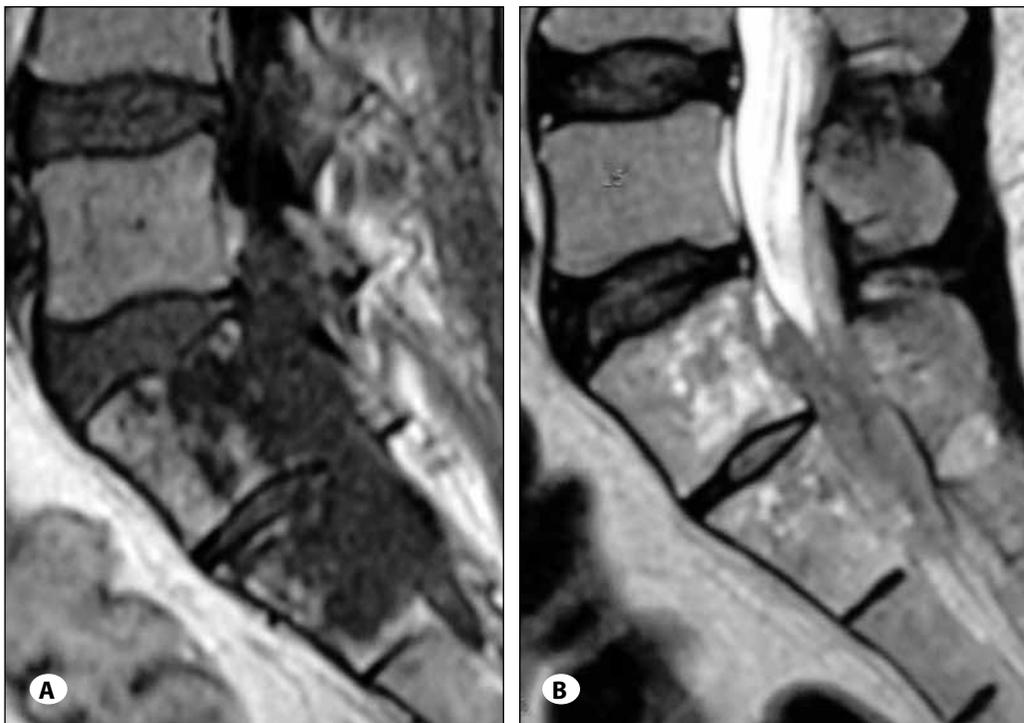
MRI scan of lumbosacral spine A) T1-weighted sagittal sections reveal isointense signal changes in S1 and S2 bodies B) T2-weighted sagittal sections reveal hyperintense signal changes in S1 and S2 bodies, also noted above is the isointense soft tissue lesion extending into the sacral epidural space.
